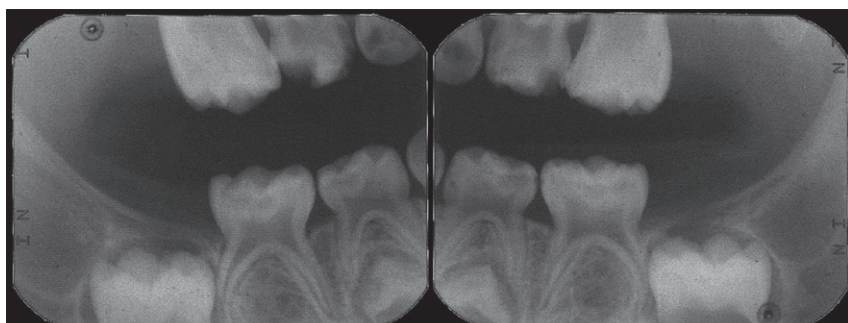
Bitewing radiographs taken at the time of general anaesthesia at three years and ten months-of-age demonstrating severe caries of teeth 85 and 75, radiolucency at the bifurcation of tooth 75 and abnormal appearance of the follicle surrounding the succedaneous tooth 35
